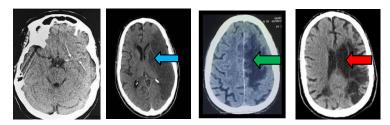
computed tomography showing tissue changes in ischemic stroke: (a) hyperdense middle cerebral artery from thrombosis, (b) acute ischemia, (b) subacute infarction, (c)chronic brain infarction.
